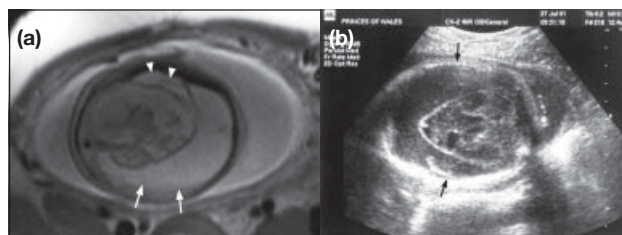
(a) Axial true fast imaging with steady state precession image showing a large right (arrows) and small left subdural haematoma (arrow heads) with fluid-fluid level. The foetal brain was underdeveloped and displaced to the left. (b) Transverse ultrasonographic section of the foetal brain showing bilateral subdural haematomas (arrows)
